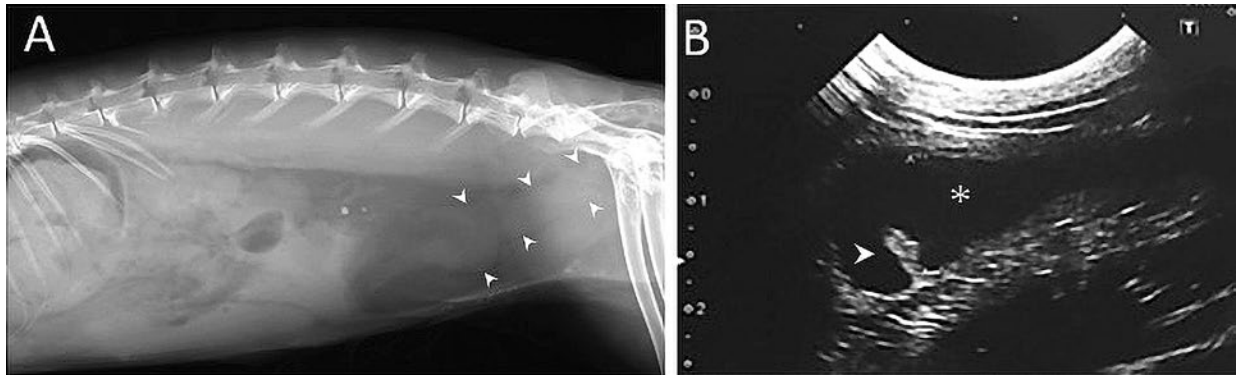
(A) Lateral abdominal radiography of an adult female pet rabbit (*Oryctolagus cuniculus*) exhibiting severe anemia revealed cylindrical soft tissue masses (arrowheads) occupying the caudal abdomen. (B) Ultrasonography of the caudal abdomen of an adult female pet rabbit exhibiting severe anemia. The proximal vagina is dilated with fluid accumulation (asterisk) and a polypoid lesion (arrowhead) of the mucosa is observed.
